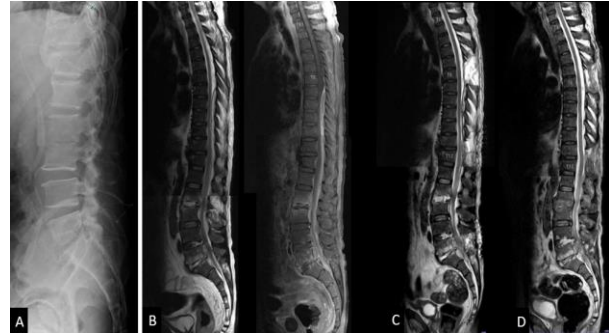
(A) Plain radiographs of the lumbar spine showing vertebral endplates destruction of L2/3 and L5/S1 (B) Pre-operative sagittal T2W & T1W with gadolinium magnetic resonance image (C) Post-operative sagittal T2W magnetic resonance images at one week (D) Post-operative sagittal T2W magnetic resonance image at six weeks.
